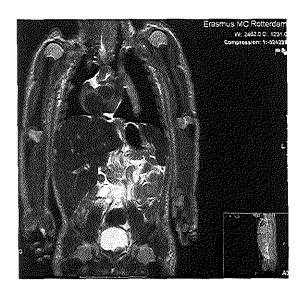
Postmortem coronal body MRI showing dextroposition of the heart, persistent left superior vena cava and normal position of liver stomach and spleen. The stomach is filled with air and pneumothorax is present after reanimation.
